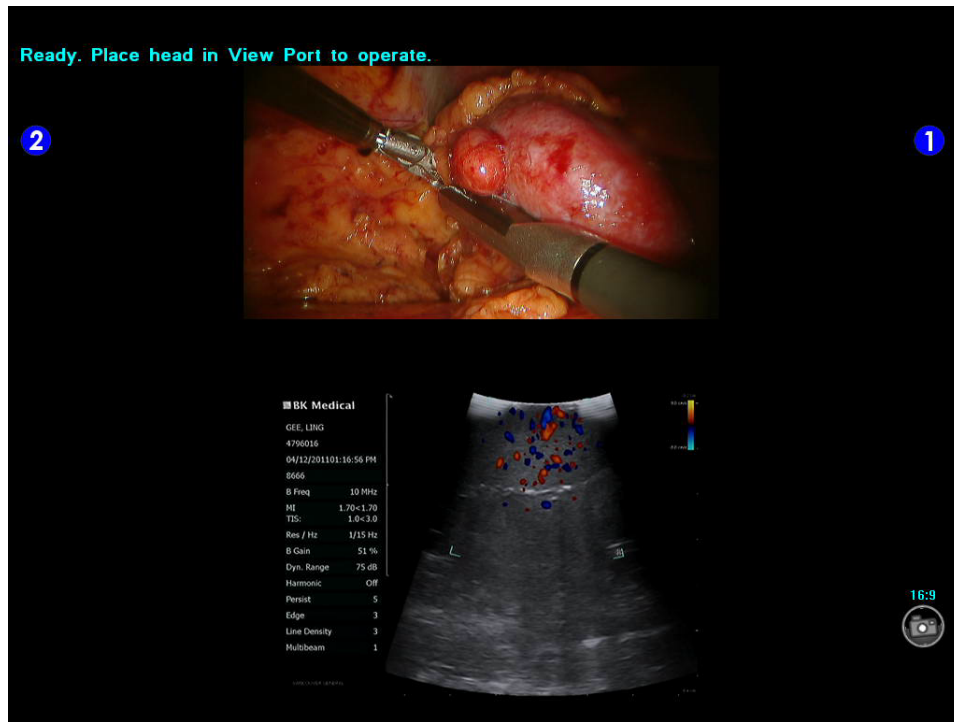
Ultrasound for partial nephrectomy using TilePro system
